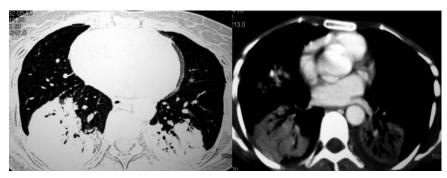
Contrast-enhanced and high-resolution computed tomography shows segmental consolidation with air bronchograms, without any lymphadenopathy or cavitation. A small pleural effusion is apparent on the left.
